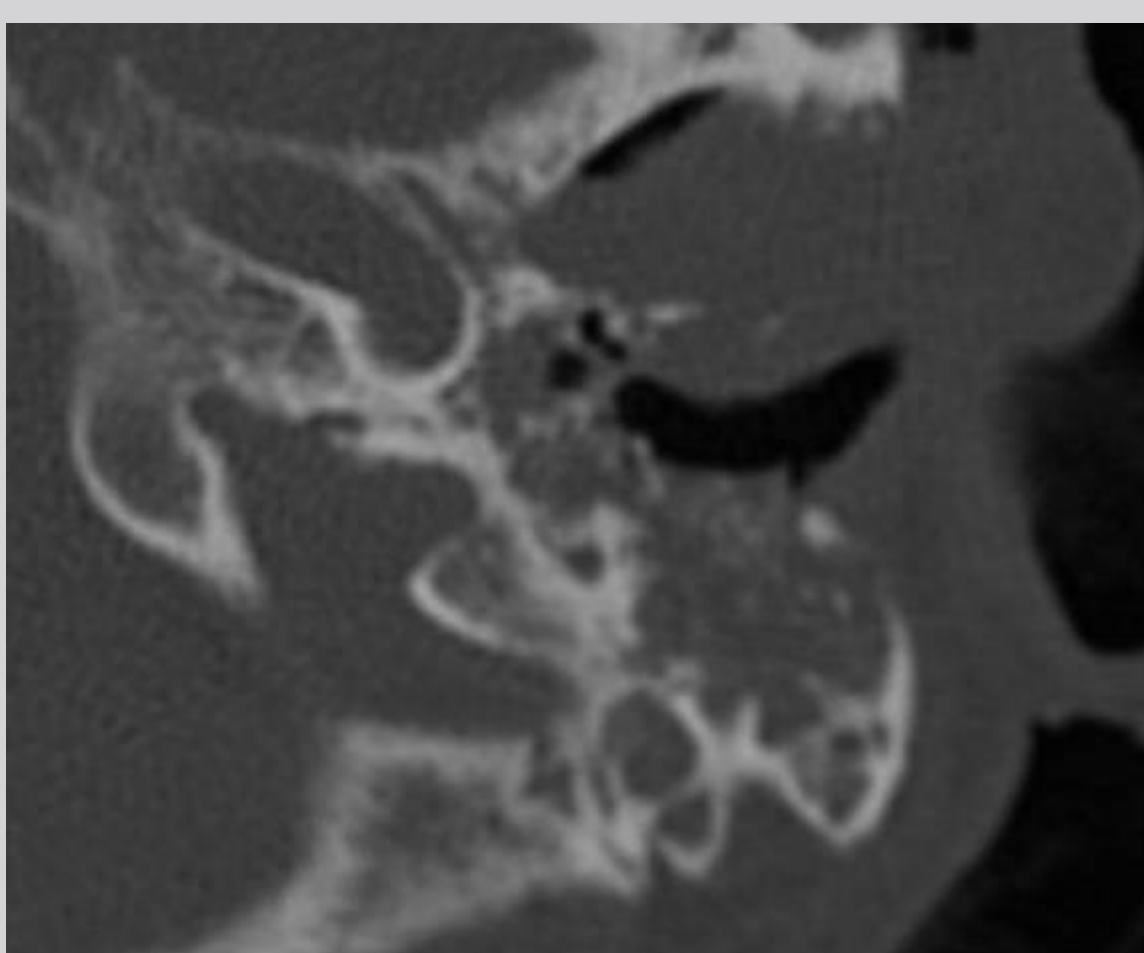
Pre-operative axial CT of left temporal bone of the patient in Case 1 showing progression of disease, with bony erosion of the external auditory canal, mastoid cavity, and middle ear.
